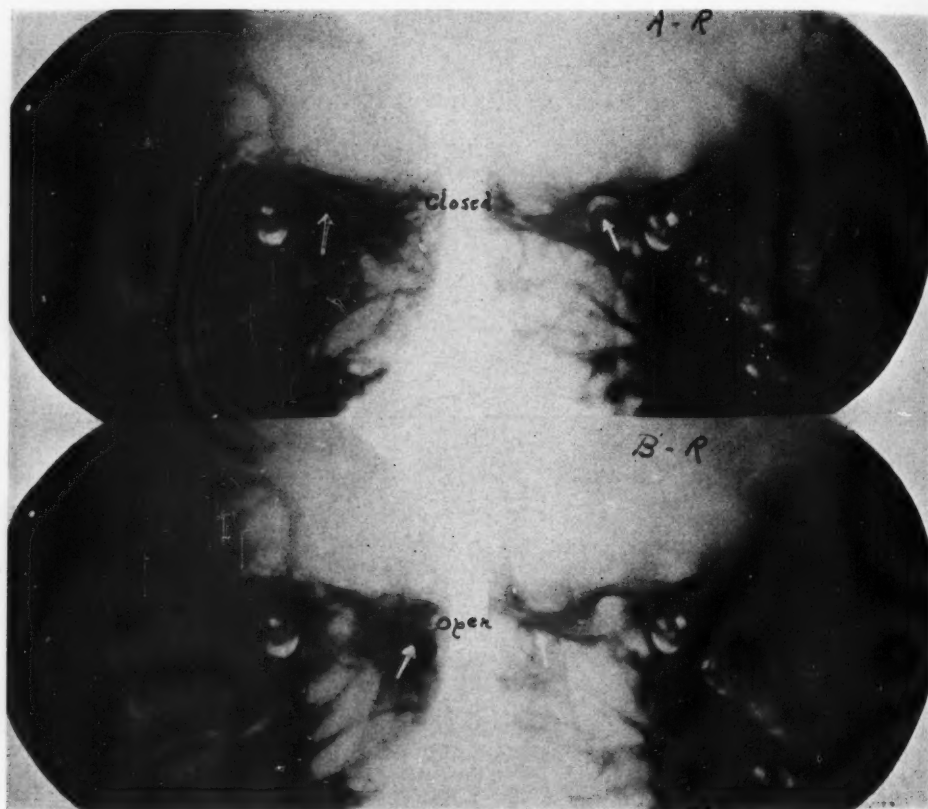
Lax temporo-mandibular joint. Case 1, Mrs. B., aged 54. *Clinical Symptomatology*.—Grinding noises in ears and slipping of jaw backward on closure of the jaw for past three years. Taste disturbance, "copper" taste, and dryness of mouth at all times. Intermittent impairment of hearing, but hearing tests showed only very mild degree of catarrhal deafness. Edentulous mouth for ten years. *Roentgenological Findings*.—Extreme anterior excursion of the condyle to the tubercle; normal position and absence of erosion of the condyles within the glenoid fossa. *Treatment*.—Dental plates replaced, opening the bite. *A-L*, Closed position, left mandibular joint; *A-R*, Closed right mandibular joint; *B-L*, Open left mandibular joint; *B-R*, Open right mandibular joint.
